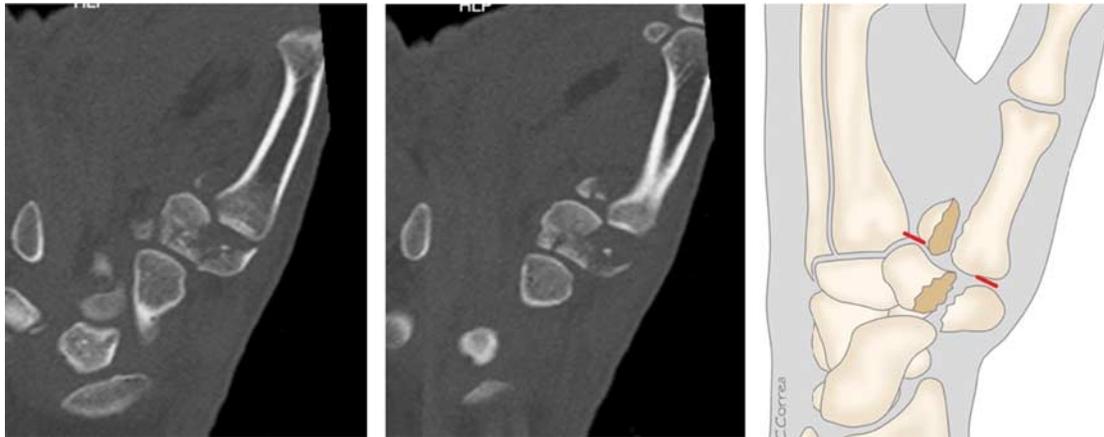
For Bennett and trapezium fractures, a CT scan is recommended to get a better detailed view and understanding of every piece of bone. In these cases, the surgeons can see the fracture from different directions and can plan the surgery better.
